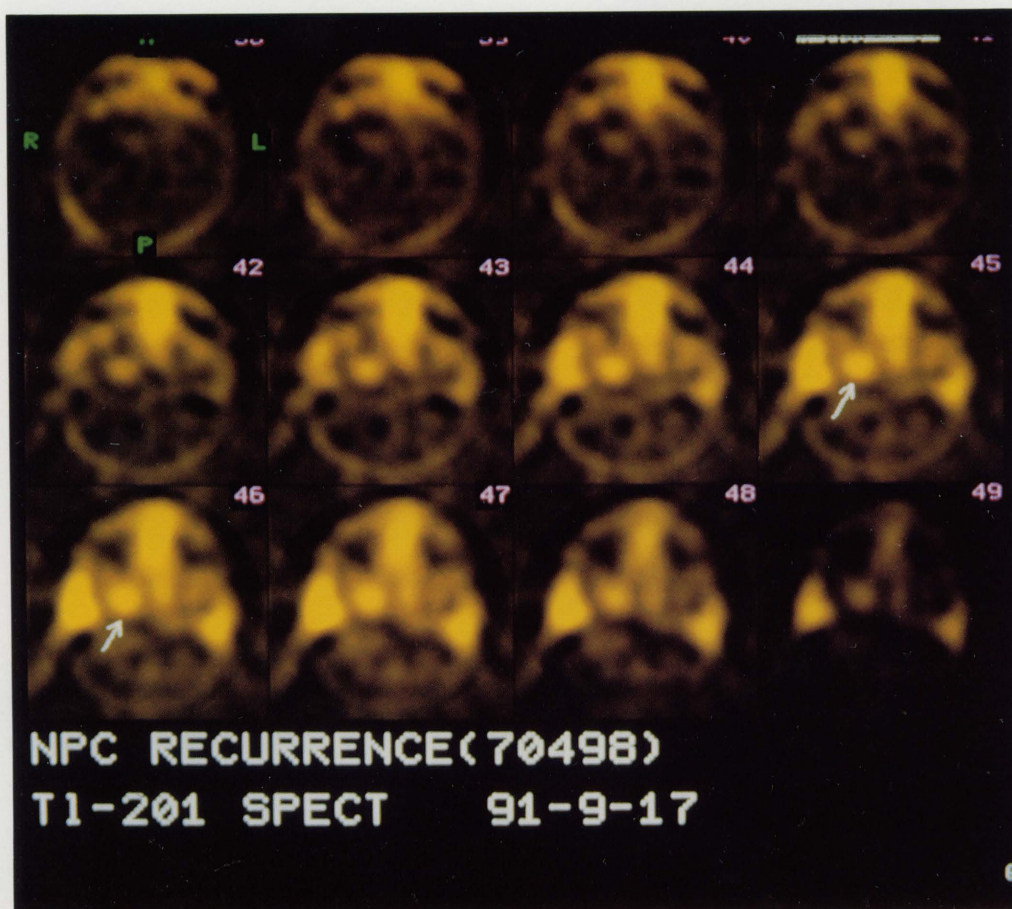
A-C. Case 4 in Table 1, A 70-year-old male with NPC. A. T1-weighted transaxial MR image showing a low intensity lesion spreading from retropharyngeal space to skull base. B. Tl-201 SPECT clearly indicates increased uptake by the recurrent lesion detected by MR image. C. Comparison between Ga-67 and Tl-201 SPECT images. Tl-201 delineates the recurrent lesion more definitively than Ga-67.
